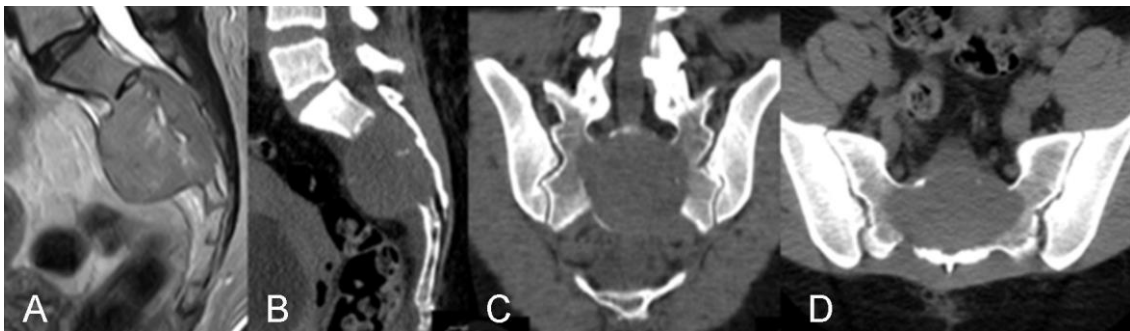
GCT of the sacrum, A. axial MRI image (T1 sequence), B. sagittal CT image, C. coronal CT image, D. axial CT image
